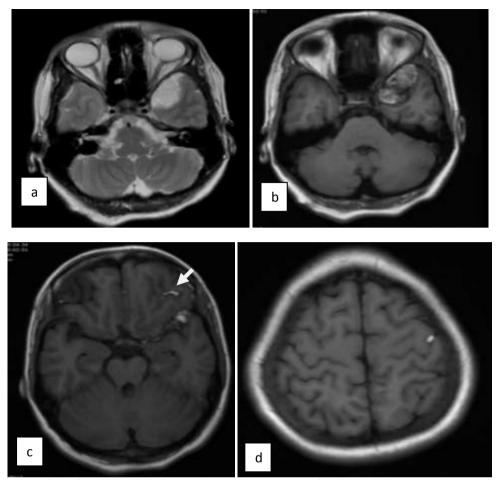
On (a) Axial T2W, (b,c,d) Axial T1W MR image the lesion is hyperintense on T1 weighted images, heterogeneous signal on T2 weighted images. T1 hyperintense foci are seen in sulcal spees of left frontal lobe (arrow in c).
